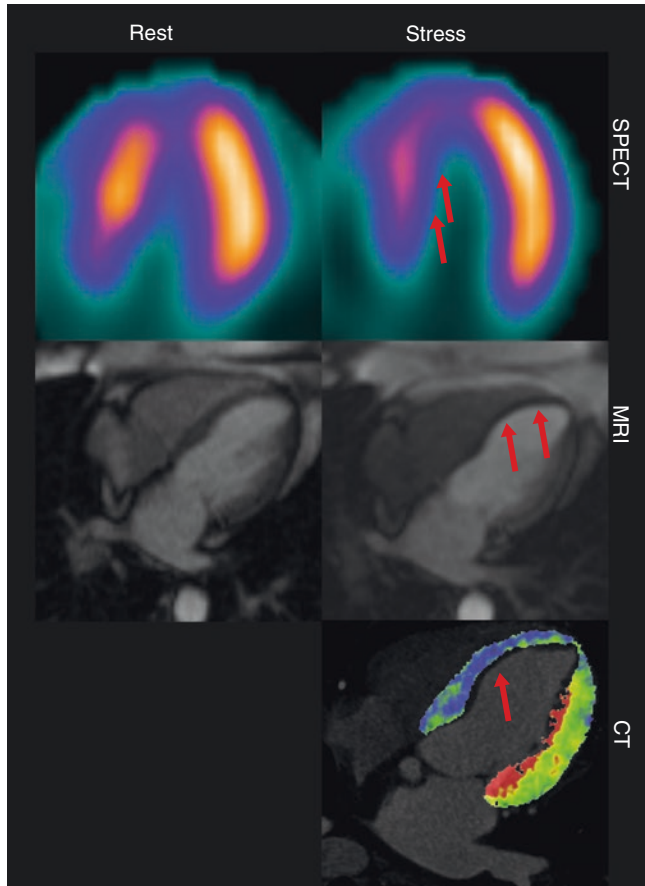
Rest and stress perfusion images made by SPECT and MRI. For dynamic CTMPI stress imaging only could be sufficient
